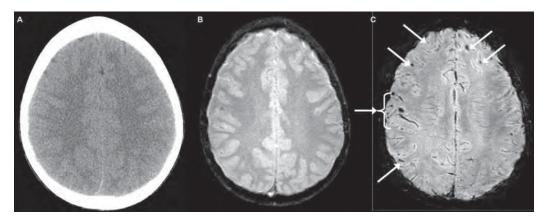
This 12 year-old male had sustained a concussion in a skate-boarding accident. Eyewitness accounts estimate LOC to be approximately 7 minutes, but in the ER the patient was alert and not amnesic. However, because of the positive LOC a CT scan was performed (A), followed by the more routine GRE sequence (B) which revealed only a hint of hemosiderin deposition, however, the susceptibility-weighted sequence (C) clearly demonstrated multiple foci of hemosiderin deposition (see arrows). (Reproduced by permission from Jill Hunter, M.D., Texas Children's Hospital, Houston, Texas).
